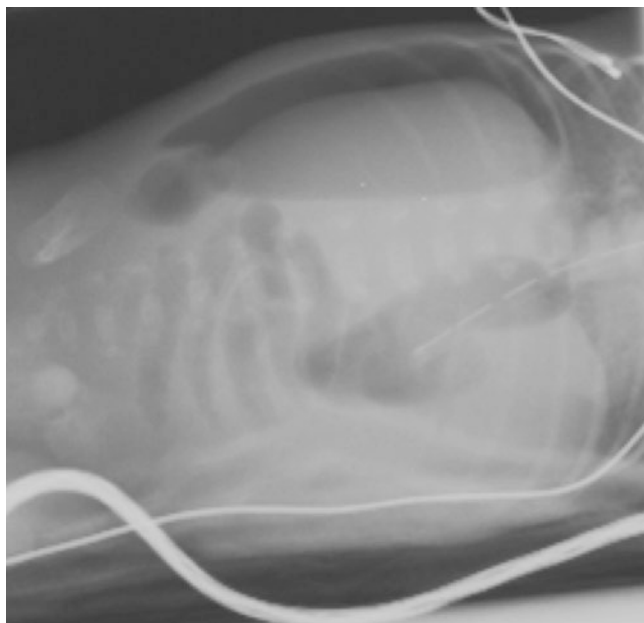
Lateral radiograph of a neonate with NEC. The neonate was positioned in the left lateral decubitus position with a multi-orifice gastric tube in the stomach. Free air is evident against the right (*upper*) lateral abdominal wall, outlining the liver and falciform ligament (Courtesy of Dr. YH Lee, Division of Pediatric Surgery, Strong Hospital, University of Rochester, Rochester, NY)
